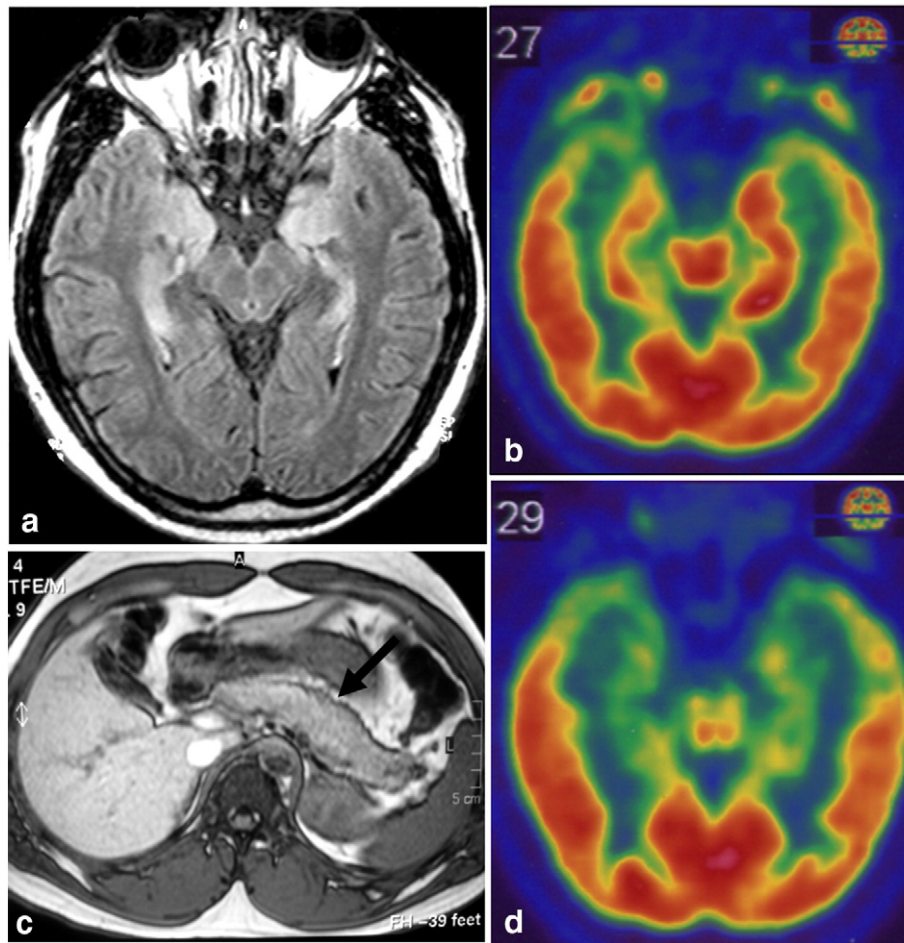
Limbic encephalitis and pancreas enlargement. (1a) Axial T2-FLAIR-weighted brain MRI showing intense signal in the amygdalae and hippocampi. (1b) Axial 2-[18F]-fluoro-2-deoxyglucose brain PET showing hippocampal hypermetabolism at the start of encephalitis, predominating on the left side. (1c) Axial T1-weighted abdominal MRI showing diffuse pancreas enlargement. (1d) Axial brain PET in March 2007 when the patient's memory had improved showing hypometabolism of the hippocampi and temporal poles.
